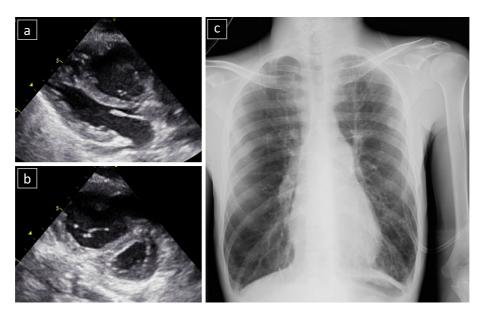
a: Echocardiography showing a D-shaped right ventricle. b: The right ventricle is dilated, compressing the left atrium and ventricle. c: A chest radiograph obtained on admission. Hyper-inflated lung fields are apparent.
